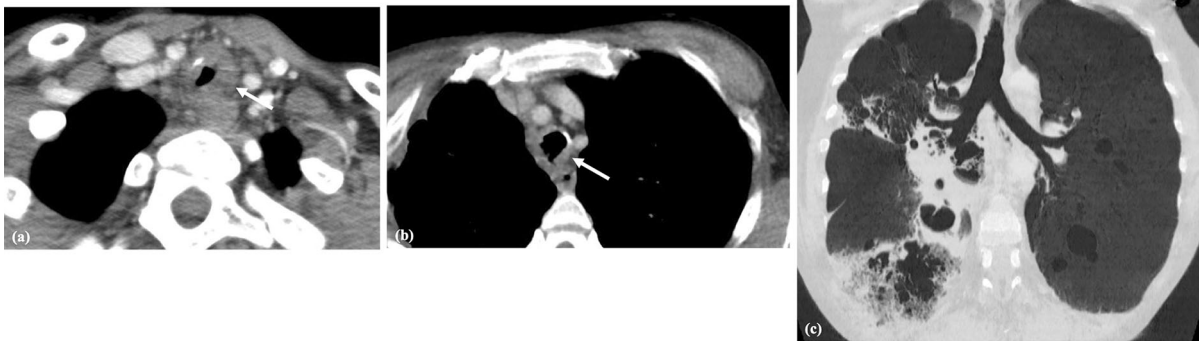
54-year-old male patient with a previous history of hepatic transplantation, presenting with cough and fever. Axial CT from upper (a) and lower (b) levels reveal concentric thickening of the tracheal walls (white arrows). c Coronal minimum intensity projection (MinIP) reconstruction shows
